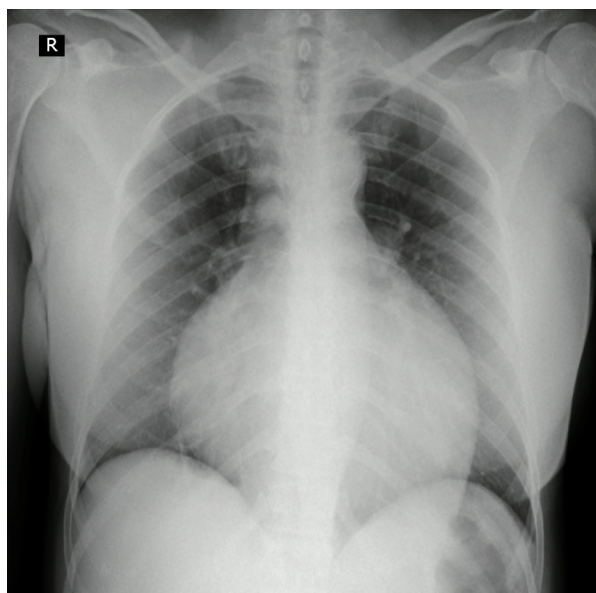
Chest X-ray. Global cardiomegaly with enlarging cardiothoracic ratio and "water bottle" configuration.
